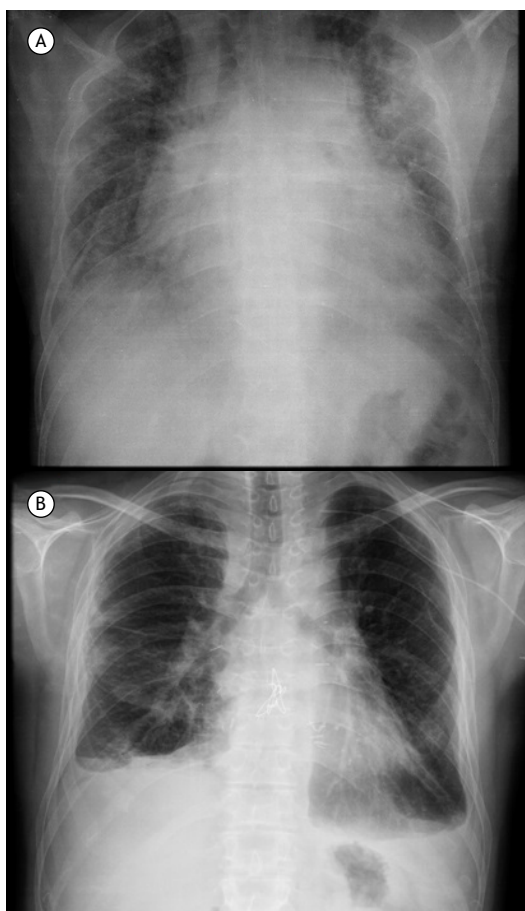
Chest X-rays: in the preoperative period (A); and six months after transplantation (B), showing significant cardiac remodeling.
